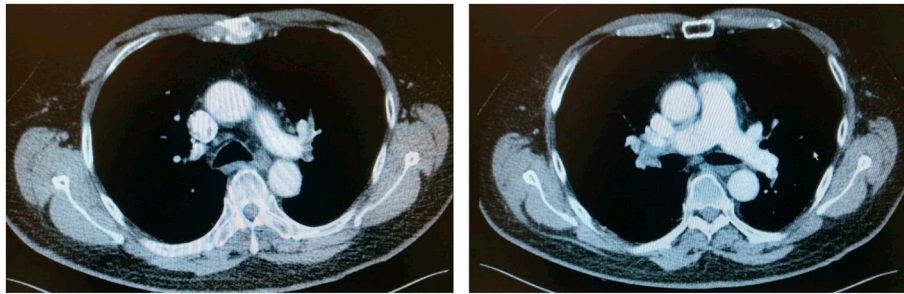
CT chest showing bilateral pulmonary embolism involving secondary and segmental branches.
